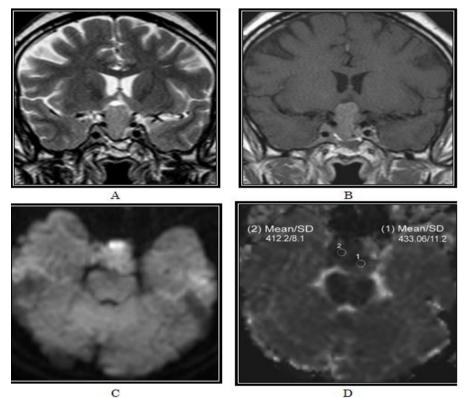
A- Coronal T2WI revealed hyperintense sellar, supra sellar, infra sellar & right para sellar lesion. B- Coronal T1WI Post Gd DTPA revealed homogeneous enhancement of the lesion. C- Axial DWI displayed hyperintensity of the lesion which is consistent with restricted diffusion. D- ADC map revealed hypointensity of the lesion with ADC value $0.42 \times 10^{-3} \text{ mm}^2/\text{s}$.
